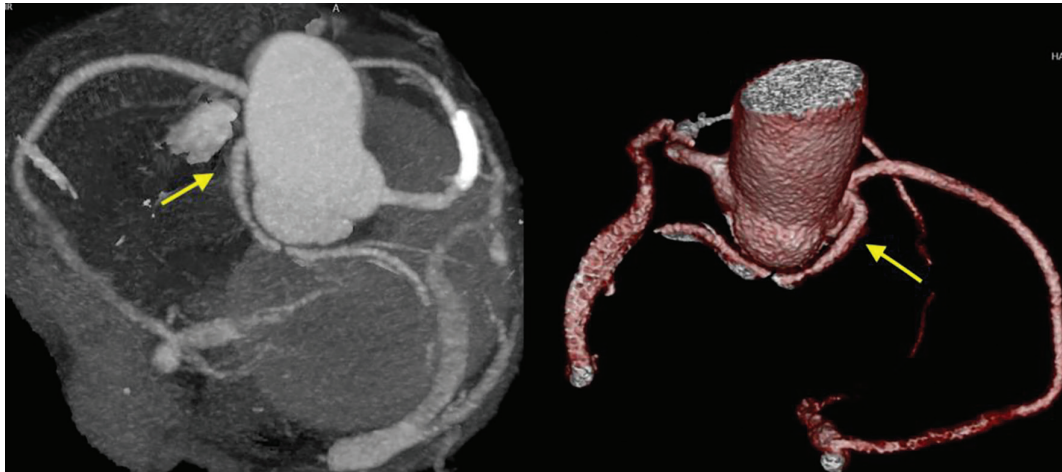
Multislice computed tomography coronary angiography revealed an anatomical variant of the left circumflex coronary artery, originating from the right coronary cusp and coursing posterior to the aorta within the left atrioventricular groove
